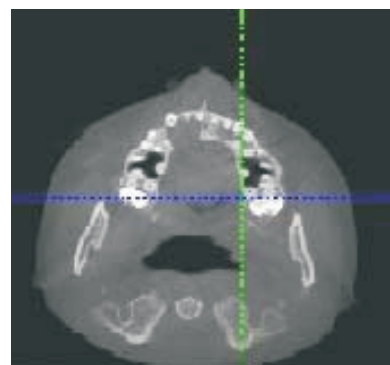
CBCT image -occlusal view
